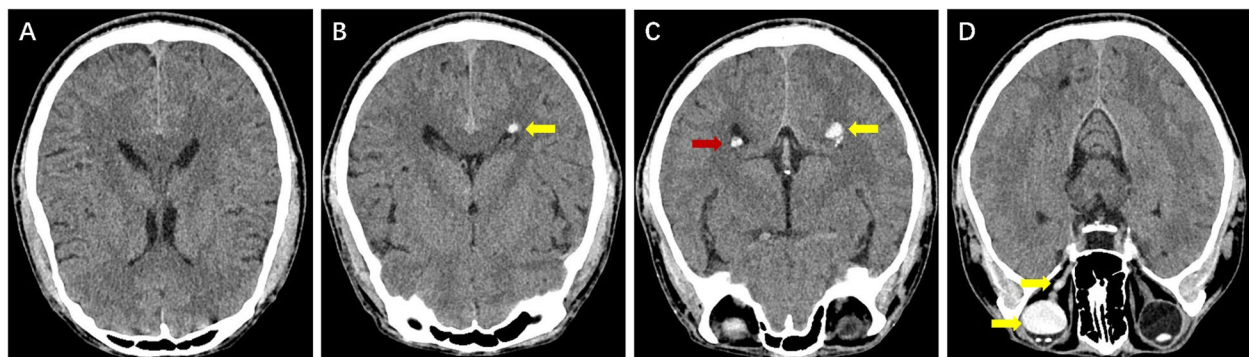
Nonenhanced brain CT in the prone position demonstrated hyperdensities in the Posterior horn of left ventricle (A–C, yellow arrows), calcification was indicated (C, red arrow), as well as in the right eye globes and in the right optic nerve, and the right optic nerve had a larger density than the left, which was close to intraocular silicone oil (D, yellow arrows)
